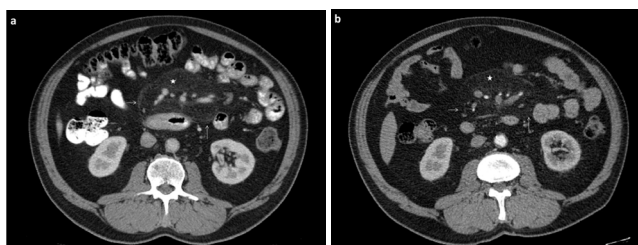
A 59-year old male patient with lung cancer. Baseline CT (a) and follow-up CT (b) scans demonstrate decreased MP findings. Density of mesenteric fat (asterisk) slightly decreased. Also lateral border of pseudocapsule can not be differentiated clearly (arrow) when comparing with baseline CT scan.
